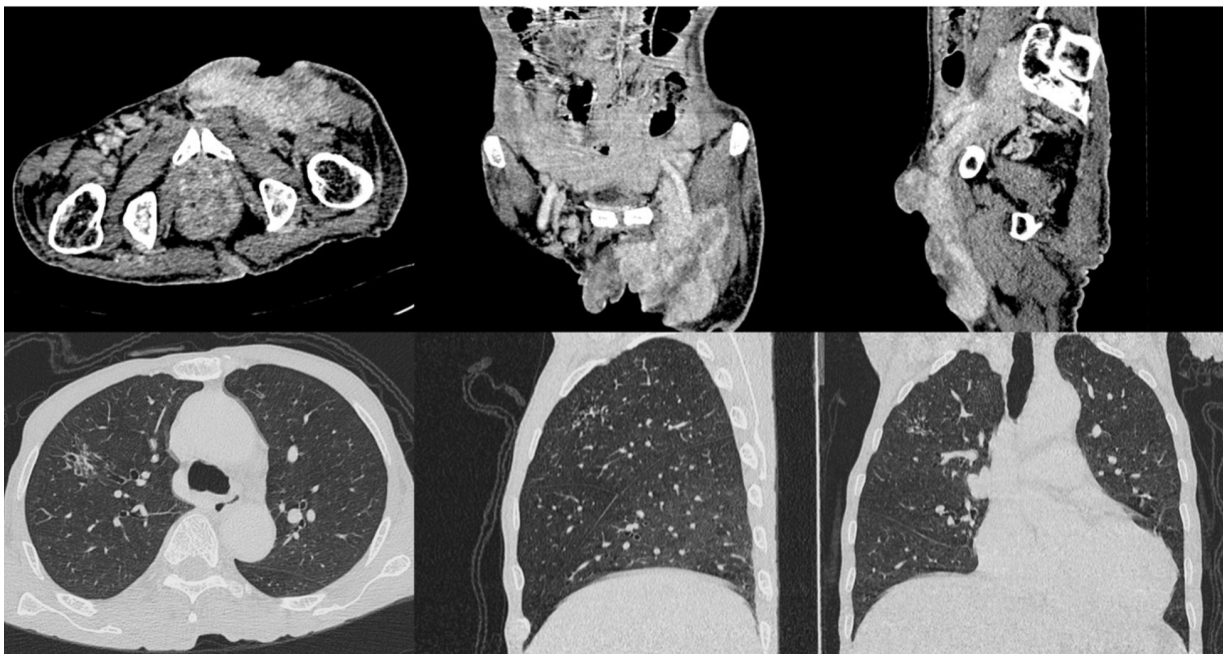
Repeated CT scan of thorax, abdomen and pelvis post chemotherapy showed the left inguinal heterogeneously enhancing mass was larger, measuring 6.1 cm x 14.5 cm x 16.7 cm (AP x W x CC), extending into the left pelvic region. This mass encases part of the left external iliac vein and part of the left common and superficial femoral veins, with no opacification of these vessels seen in the region of the mass. Resolving right upper lobe tree in bud densities also noted
